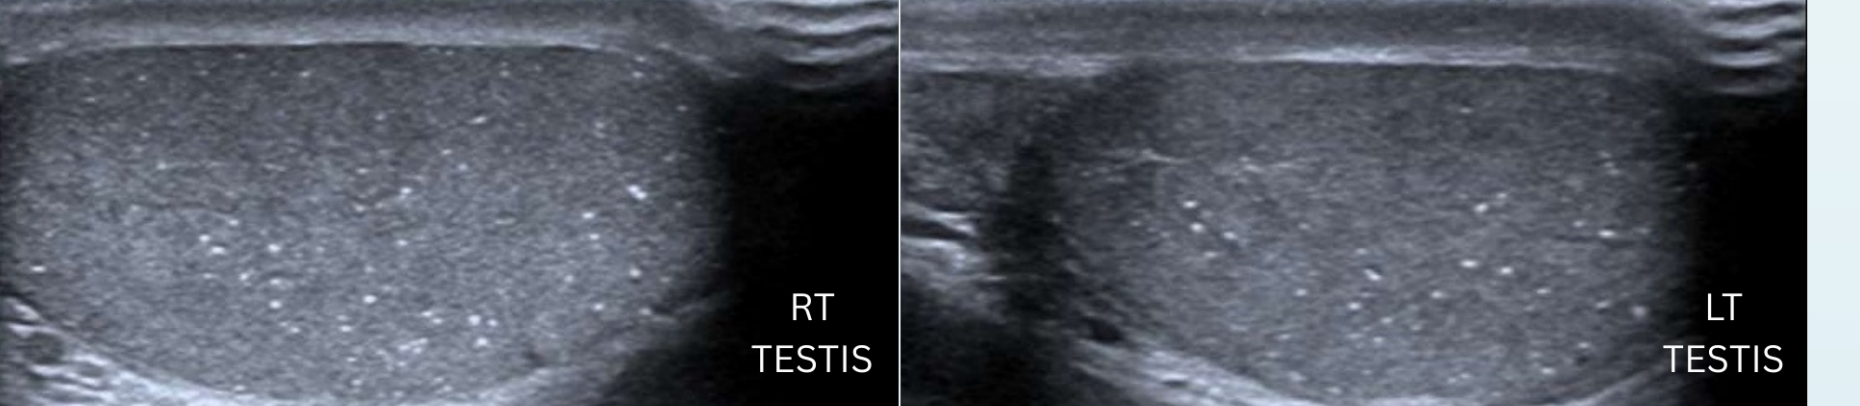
Both testicles contained diffuse micro echogenic foci (seen as the white speckles in the images). Ultrasound images from KEMH Radiography Department.
